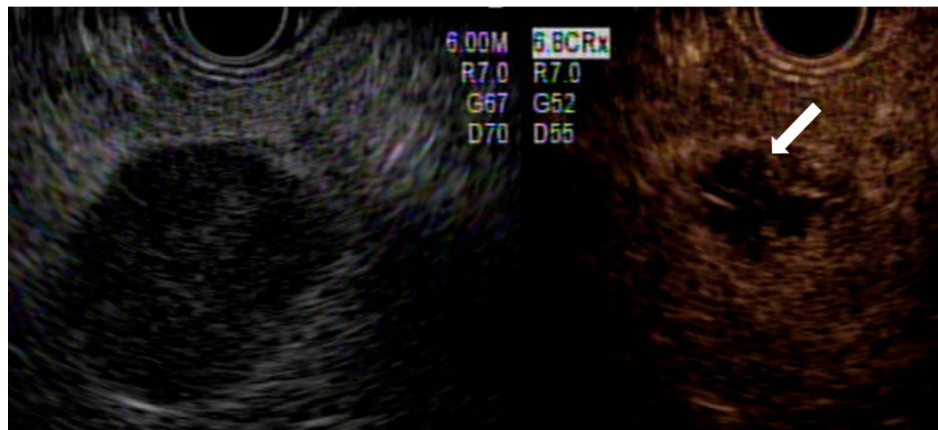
Contrast-enhanced-EUS showing a nonenhanced necrotic portion (arrow) with an enhanced viable tumor. EUS: Endoscopic ultrasound.
